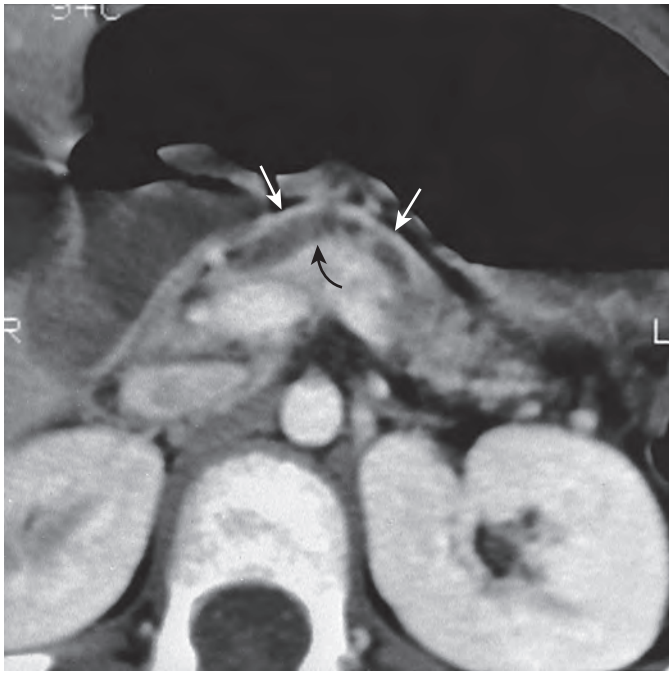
CT findings of chronic pancreatitis. CT demonstrates thinning of the pancreatic parenchyma (straight arrows) with dilation of the pancreatic duct (curved arrow) in a 5-year-old girl with chronic pancreatitis.
